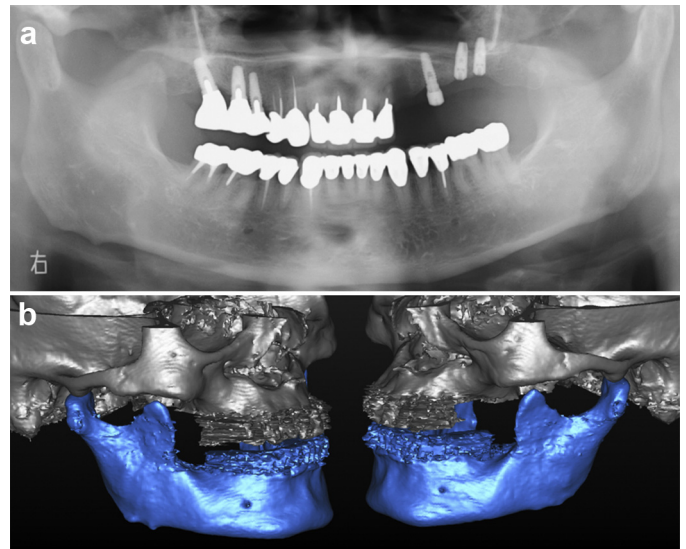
Panoramic radiograph (a) and 3DCT (b) showing a prominent mandibular angle bilaterally.
